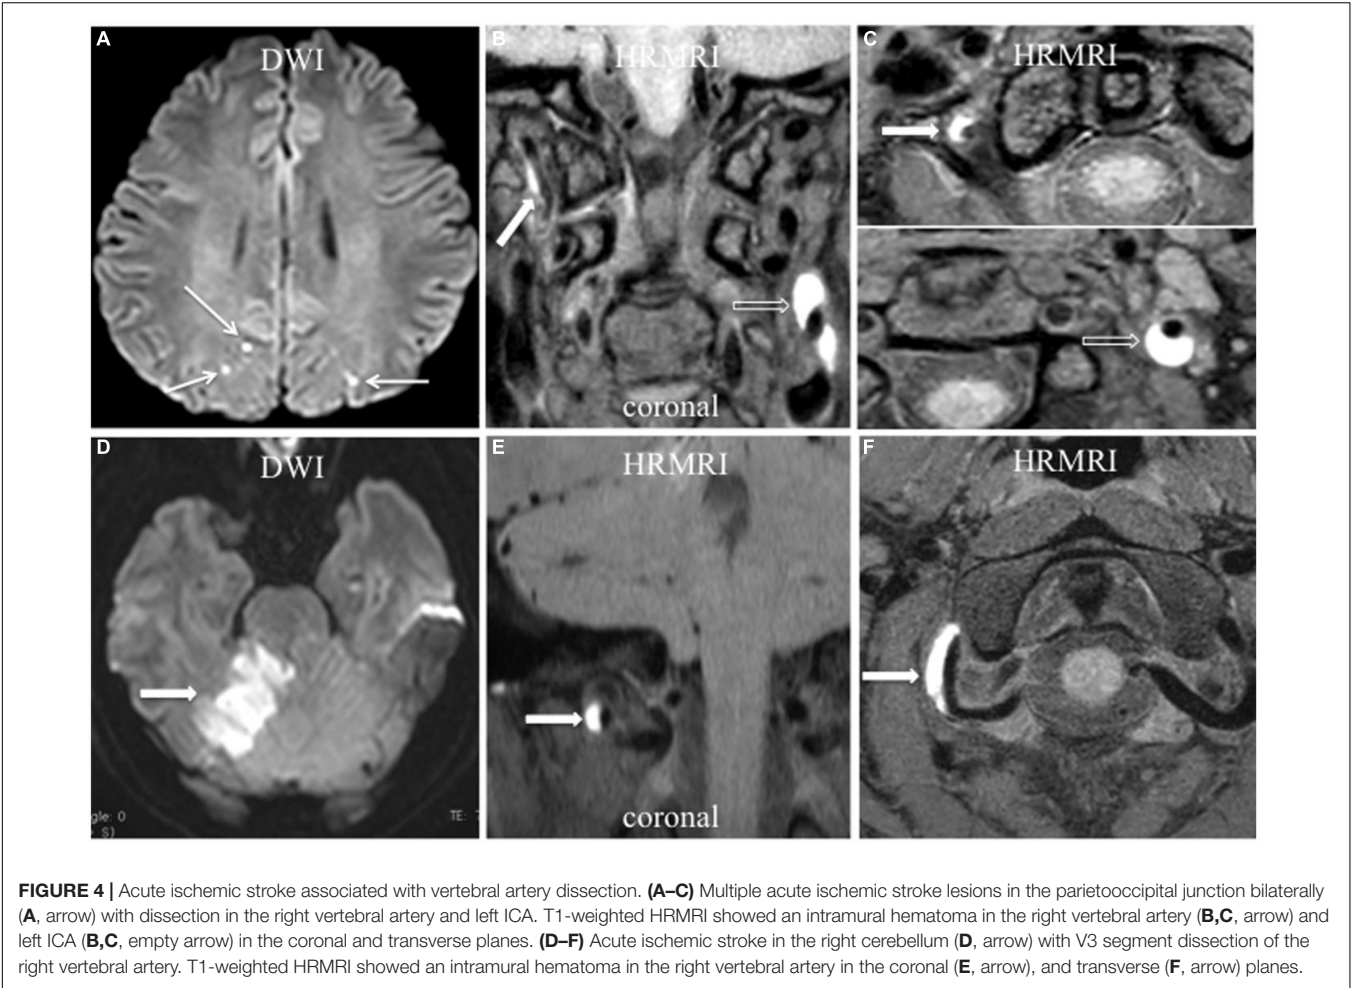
Acute ischemic stroke associated with vertebral artery dissection. (A–C) Multiple acute ischemic stroke lesions in the parietooccipital junction bilaterally (A, arrow) with dissection in the right vertebral artery and left ICA. T1-weighted HRMRI showed an intramural hematoma in the right vertebral artery (B,C, arrow) and left ICA (B,C, empty arrow) in the coronal and transverse planes. (D–F) Acute ischemic stroke in the right cerebellum (D, arrow) with V3 segment dissection of the right vertebral artery. T1-weighted HRMRI showed an intramural hematoma in the right vertebral artery in the coronal (E, arrow), and transverse (F, arrow) planes.
